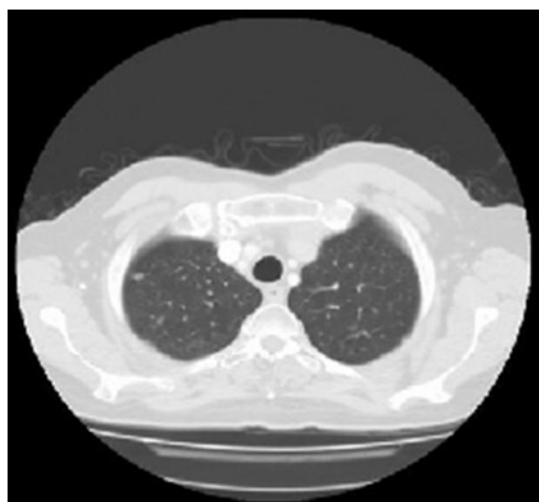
CT lung slice and its Histogram
